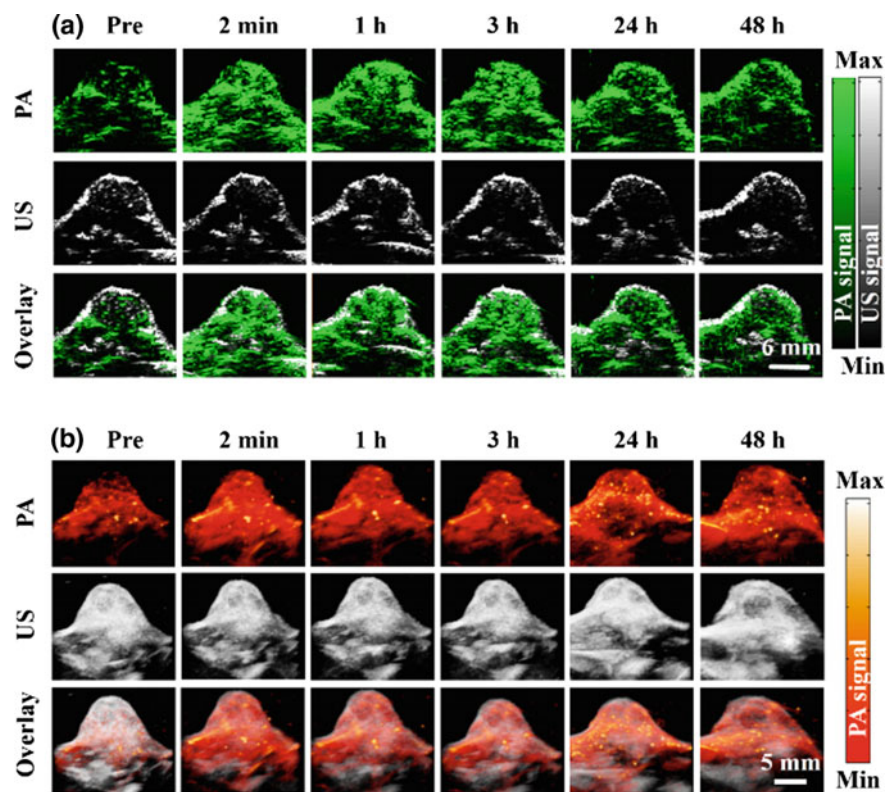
In vivo photoacoustic imaging. a B-scan and b 3D ultrasound (US) and PA images of the tumor region obtained at 2 min, 1, 3, 24, and 48 h after tail vein injection of rNGO-PEG/ICG
